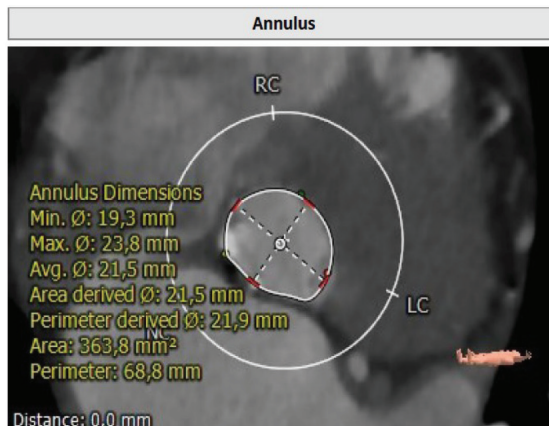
CT of aortic valve, patient No 1
